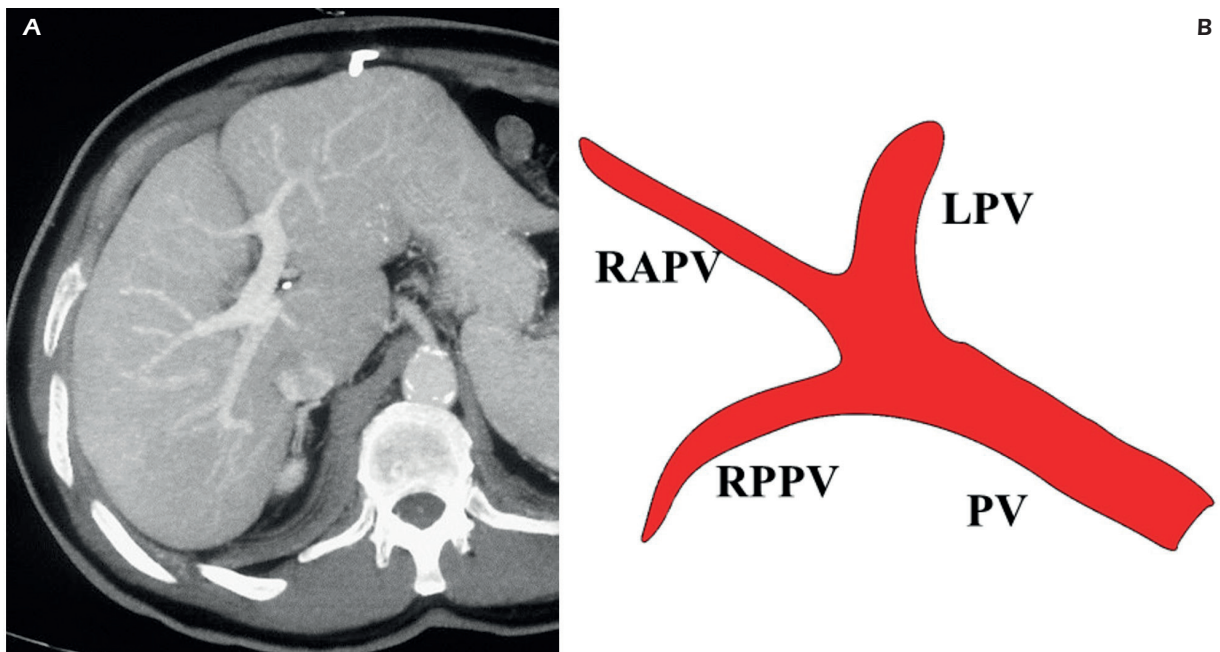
Portal vein variants – type 2. A, Contrast-enhanced MRI on portal venous phase - coronal MIP reconstruction. The right posterior portal vein originates as the first branch of the portal vein. B, PV: portal vein; RPPV: right posterior portal vein; RAPV: right anterior portal vein; LPV: left portal vein.
